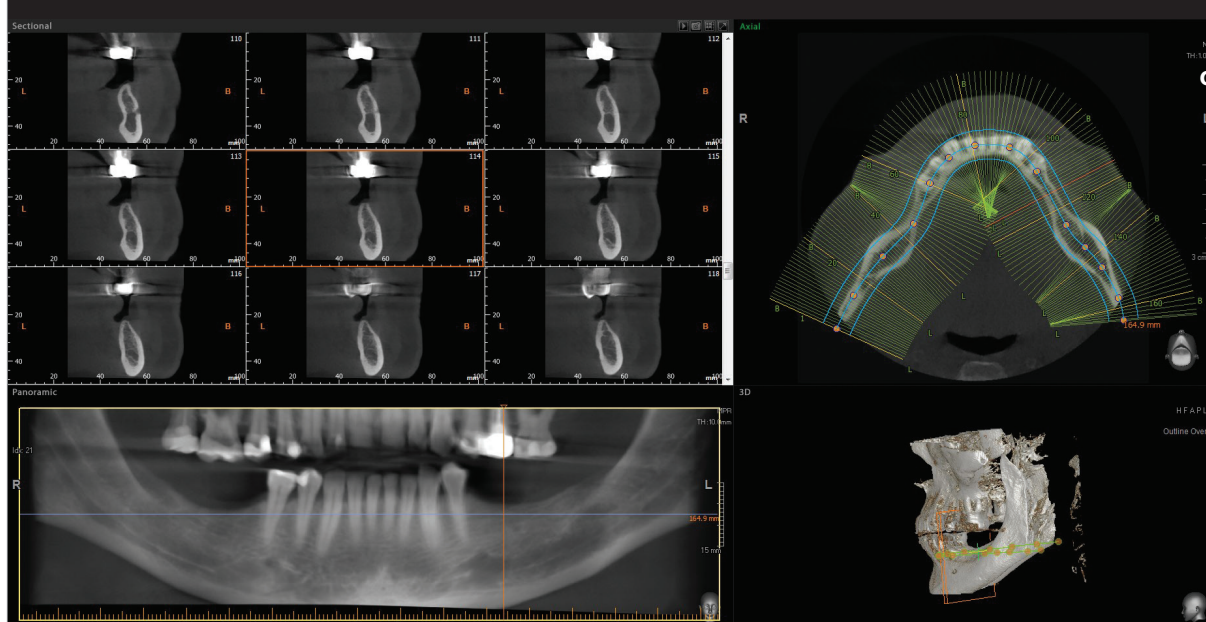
Pre-op CBCT scan showing vertical bone defects in the third and fourth quadrants.
